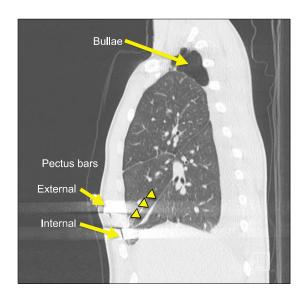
Computed tomography scan showing the multiple bullae at the apex of the right upper lobe, the sandwich pectus bars (external, internal bars) for repair of pectus carinatum, and curvilinear upward deviation of the minor fissure due to the right middle lobe entrapment into the internal pectus bar (arrow head).
